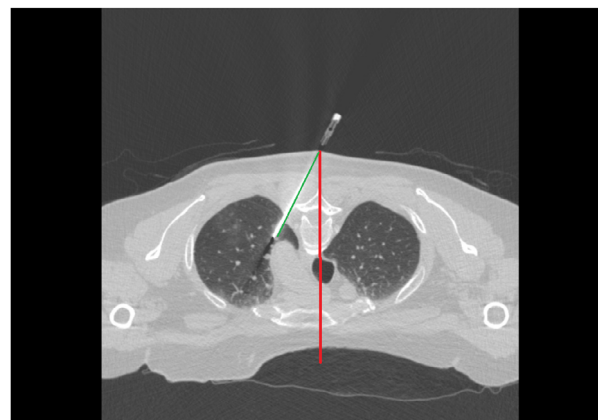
Computed tomography (CT) scan demonstrating the puncture angle to be identical to the planned angle (green laser beam), in reference to the gravity line (red laser beam)
